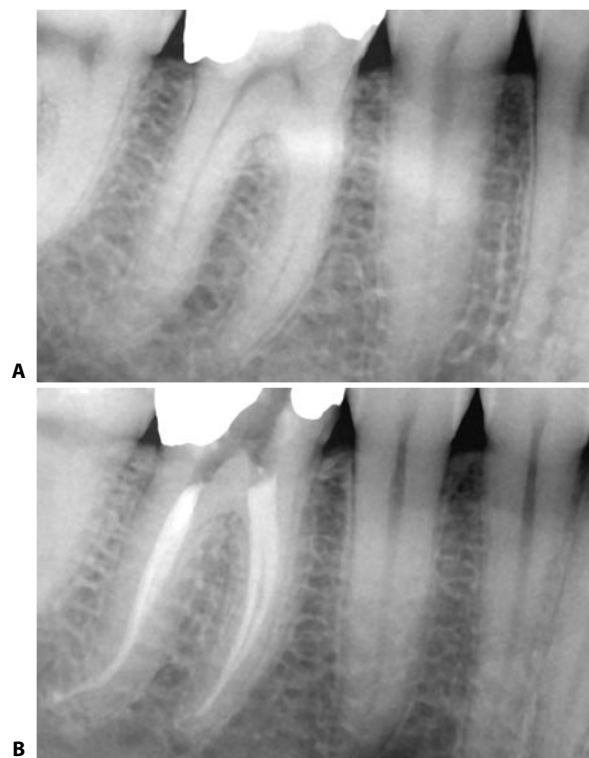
Endodontic treatment of a lower first molar. A. Preoperative radiograph. B. Endodontic obturation carried out with the Microseal Technique highlights type II anatomy according to Weine involving both roots.
